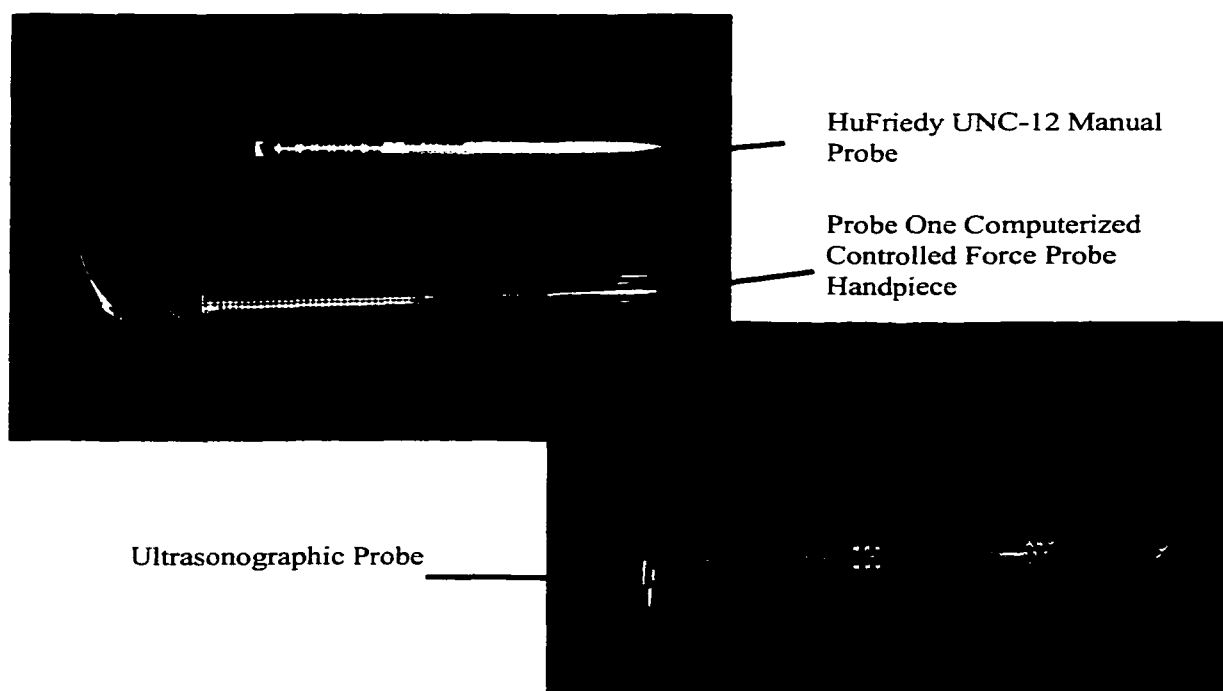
Manual and controlled force probes (top left), and the prototype ultrasonographic probe (bottom right), used in the clinical trials.
